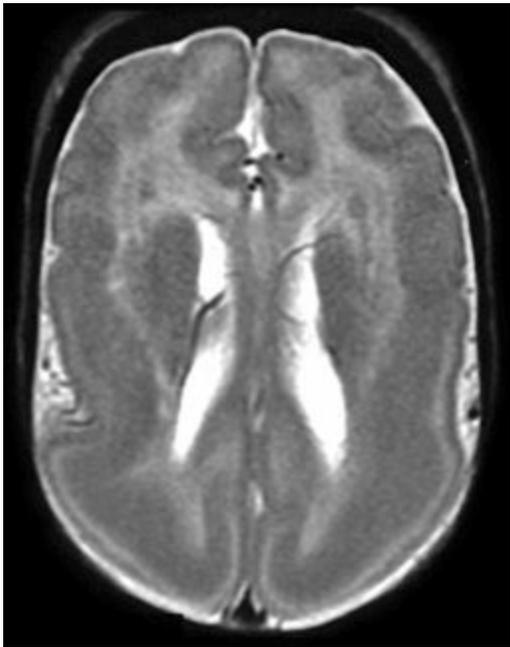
Lissencephaly. LIS1 mutation. MRI shows the typical smooth cortex predominantly affecting the posterior regions.
